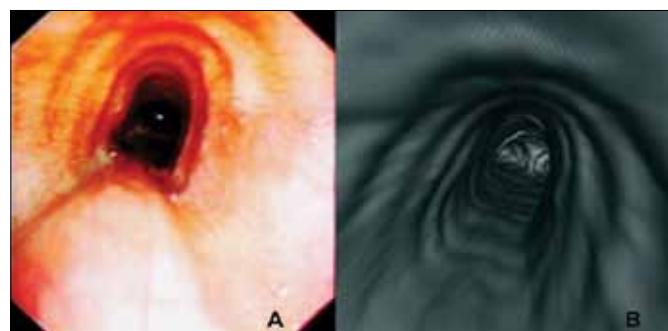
A. Case 2. During FOB, luminal narrowing was observed in all tracheal walls, with a sabre-sheath morphology in the middle and upper 1/3 parts of the trachea, and there was an 80% reduction of the intratracheal lumen during forced expiration. B shows the trachea view acquired by virtual CT
